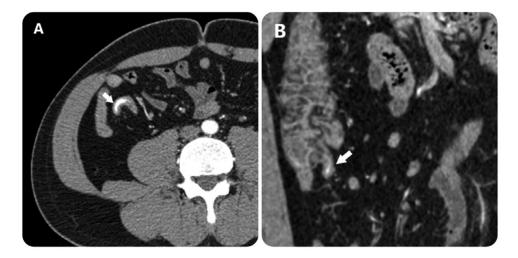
Postcontrast computed tomography image on the axial plane (A) and coronal plane (B) showing intraluminal contrast extravasation at the root of the appendix (arrow).
